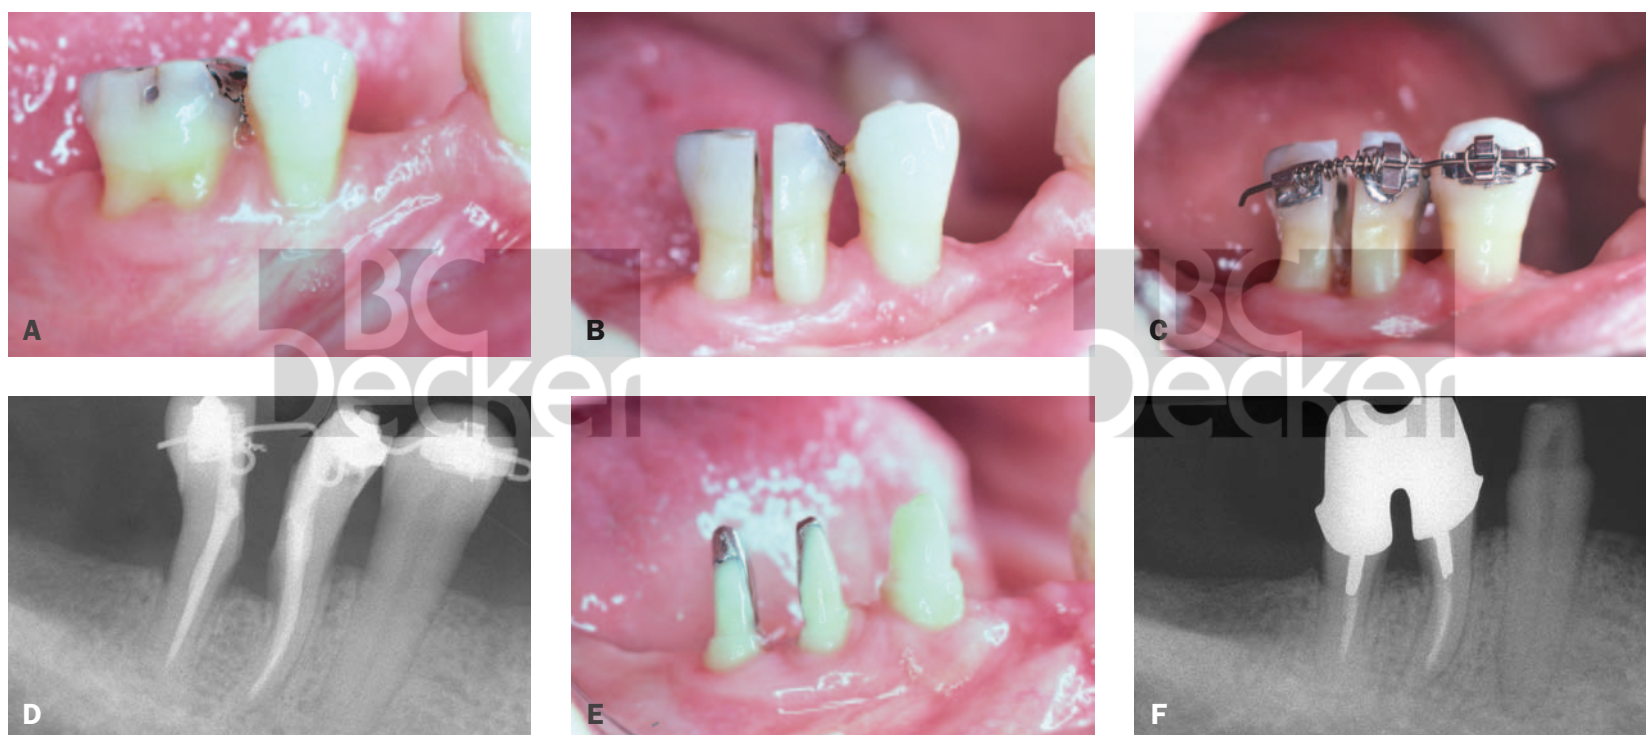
Hemisection and bicuspidization. A, Before treatment. B, Hemisection of roots. C, Orthodontic separation of roots for creation of an adequate embrasure space. D, X-ray study showing final separation. E, Individual roots prepared for crowns. F, X-ray study showing final casting in place. Courtesy of Cary Golavic, Portsmouth, NH.
